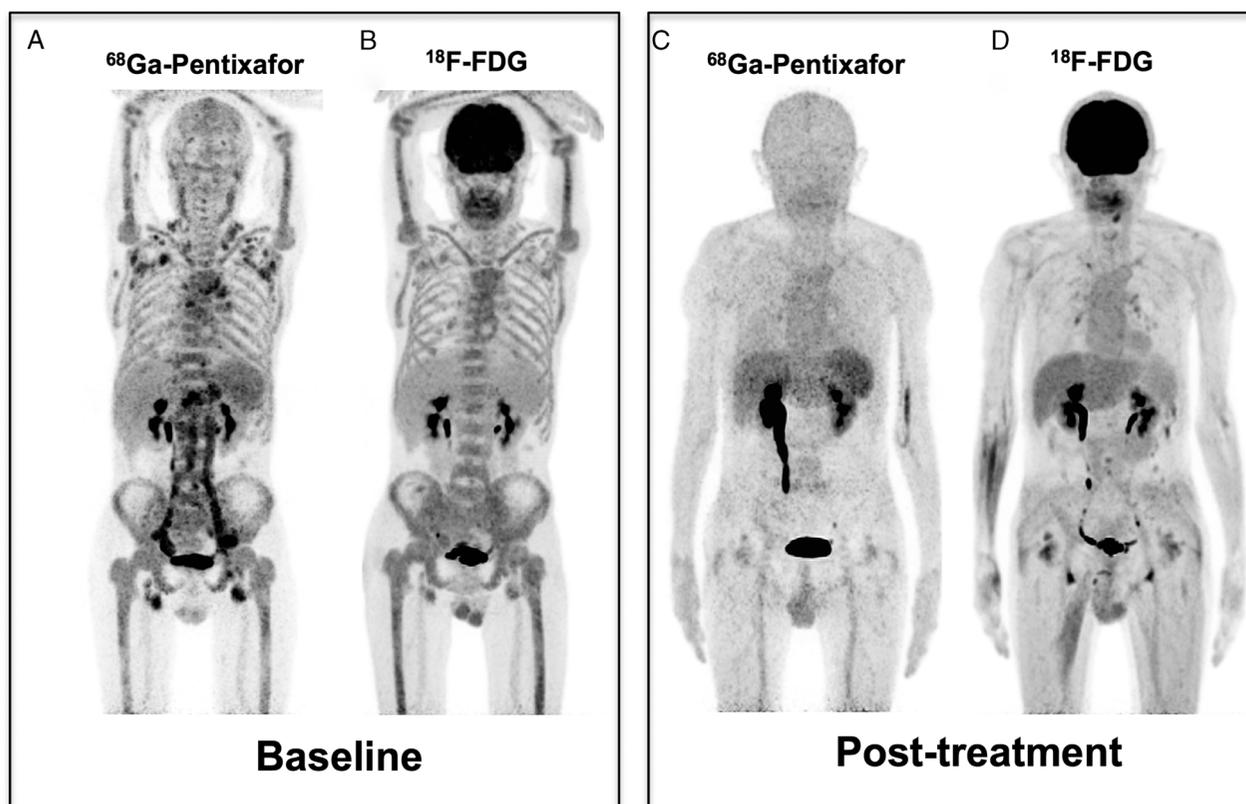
Patient 1 (male, 61 years, intermediate risk of ISS-WM) with clinical CR after 6 cycles of chemotherapy (5 cycles of R-FC, 1 cycle of R-DC). Baseline ⁶⁸Ga-pentixafor (A) and ¹⁸F-FDG (B) PET/CT showed diffusely increased uptake in bone marrow. ⁶⁸Ga-pentixafor PET/CT also detected lymph nodes, paramedullary, and nerve root involvement. Four months after completion of chemotherapy both of the follow-up ⁶⁸Ga-pentixafor (C) and ¹⁸F-FDG (D) PET/CT showed CR of the bone marrow and extramedullary disease (ISS-WM, International Staging System for WM; R, rituximab; F, fludarabine; C, cyclophosphamide; D, dexamethasone).
